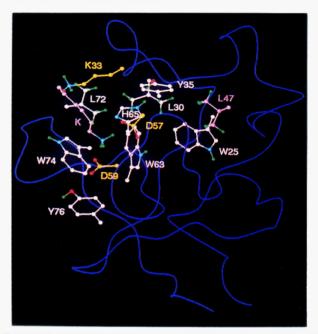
Representation of the X-ray structure of wtr-[K2_{tPA}], emphasizing the steric relationships of Y⁷⁶ to the previously identified ω -amino acid ligand binding site residues K³³, D⁵⁷, D⁵⁹, W⁶³, H⁶⁵, and W⁷⁴ and to the conformational determinants of L⁴⁷, W²⁵, and possibly Y³⁵. Selected amino acid side chains are displayed from their β -carbons on the blue ribbon, as indicated. The sequence position of amino acids begins at C¹ of the r-[K2_{tPA}] sequence and continues consecutively to the last C (C⁸²) of this domain. Most hydrogen atoms are excluded to minimize overcrowding. Aromatic and hydrophobic amino acid (W²⁵, L³⁰, Y³⁵, W⁶³, H⁶⁵, L⁷², W⁷⁴, and Y⁷⁶) side-chain carbon atoms are in white, nitrogen atoms are in blue, oxygen atoms are in red, and hydrogen atoms are in green. Amino acid side-chain carbon atoms from charged residues (K³³, D⁵⁷, and D⁵⁹) are in yellow. The side-chain carbon atoms of L⁴⁷ are in pink for emphasis, as are the side-chain carbon atoms for a pseudoligand lysine residue (K is K⁴⁹ from another [K2_{tPA}] molecule in the unit cell that is possibly inserted into the ω -amino acid binding pocket).
